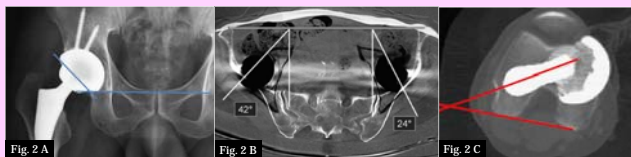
Measurement with X-ray and CT
